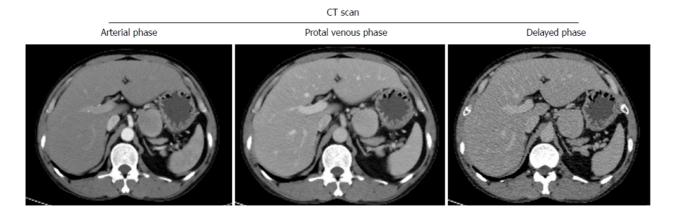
Computed tomography scans of the tumor.
